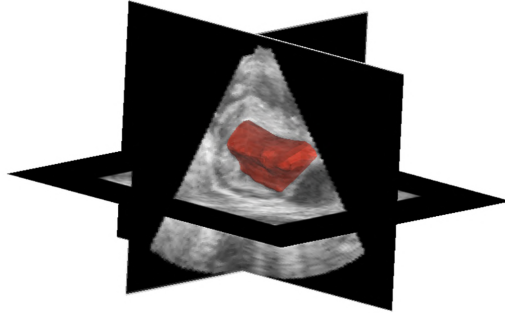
A 3D ultrasound image of the left ventricle (view from mitral valve) with the endocardial surface in red. The 3D endocardial surface was obtained by automated segmentation.
